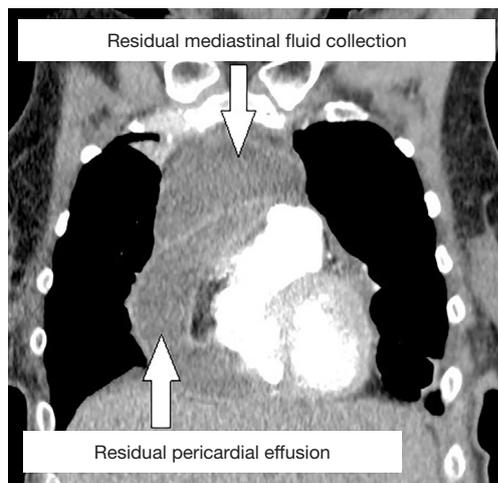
Interim coronal CT-scan with IV contrast (soft tissue window) displaying both residual pericardial effusion and residual mediastinal fluid collection as a possible indication for persistent abscess formation. CT, computed tomography; IV, intravenous.
